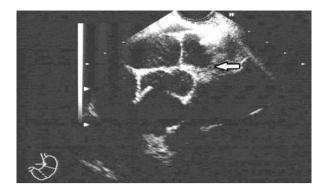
The same patient underwent EUS-FNA. This image shows the lesion (arrow) observed under EUS. EUS-FNA - endoscopic ultrasonography-fine needle aspiration
